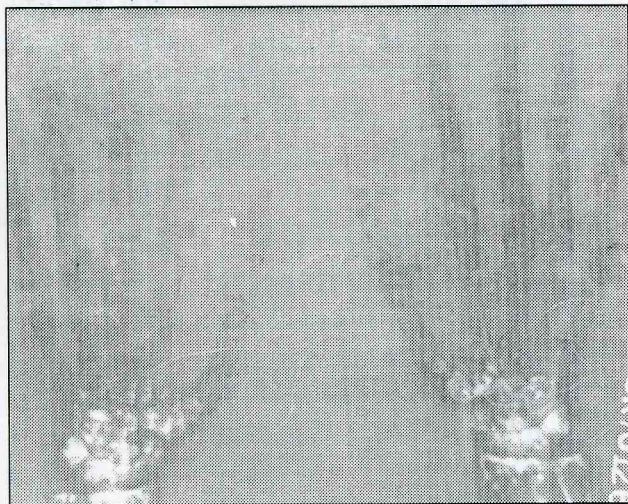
X-ray of wrist joint showing the spotted areas over metacarpal bones.
